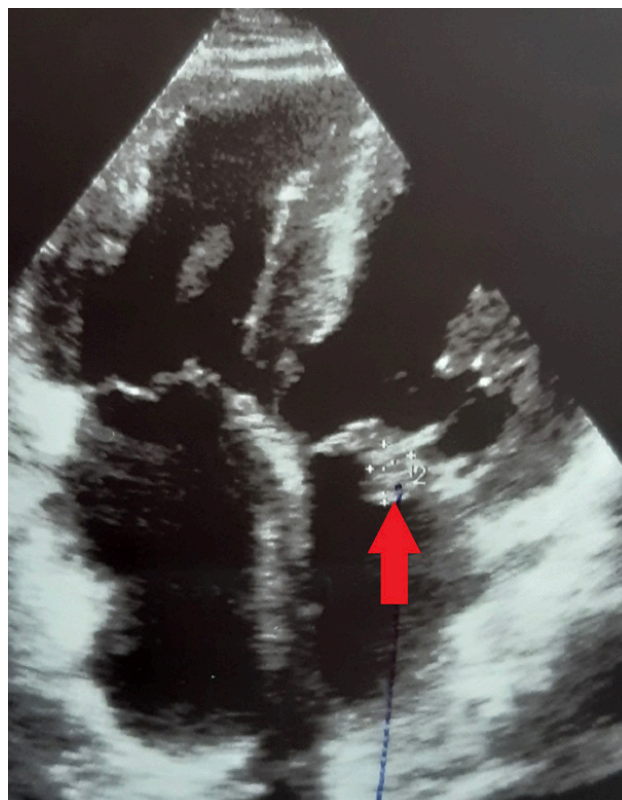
Apical four-chamber view showing a vegetation on the anterior leaflet of the mitral valve.
